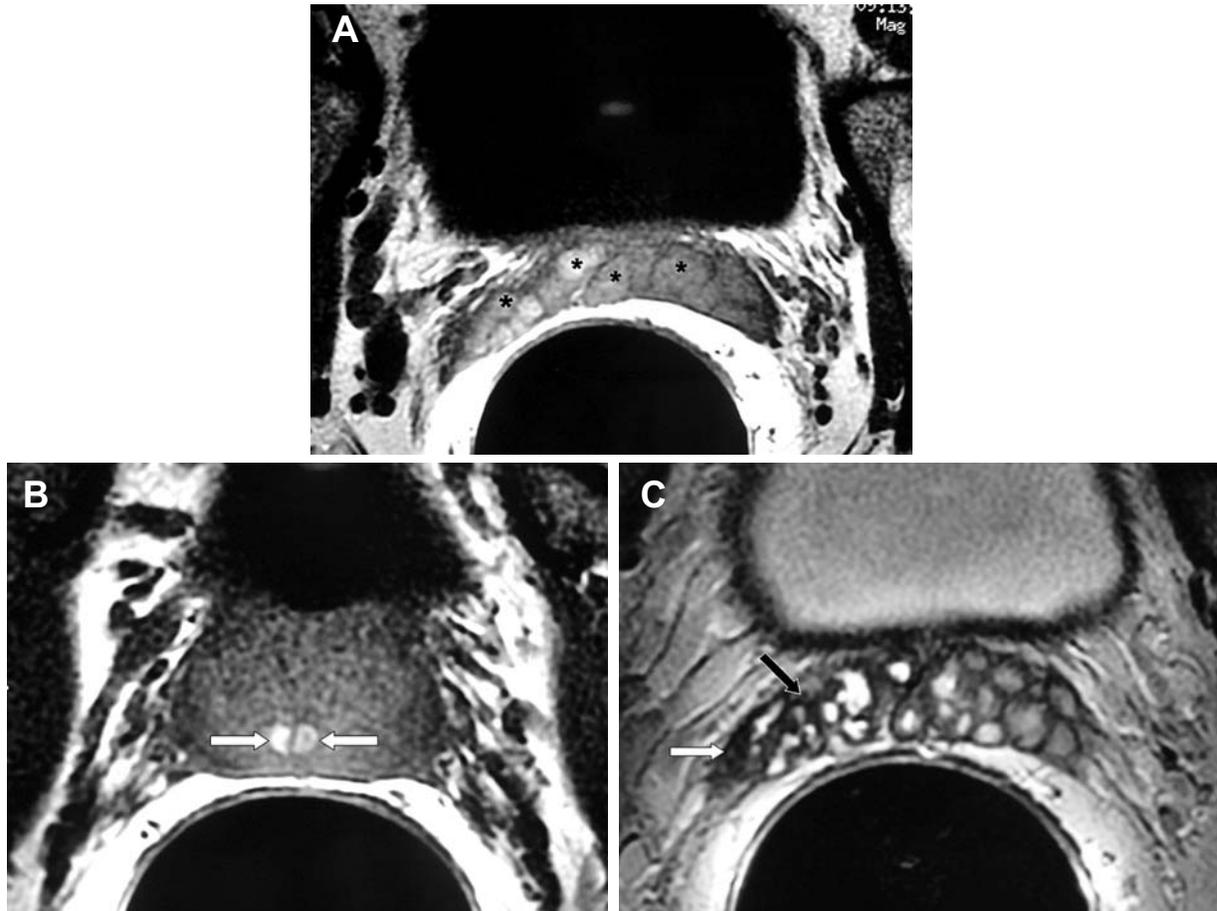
Hemorrhagic chronic seminal vesiculitis. A 62-year-old man, with history of persistent hemospermia and perineal discomfort. A) and B) E-MRI ,axial plane, T1-weighted images. Note high-signal intensity hemorrhage in both seminal vesicles (asterisk) and in both ejaculatory ducts (white arrows). C) and D) E-MRI, axial plane, T2-weighted images ,showing imaging features consistent with chronic seminal vesiculitis: diffuse thickening of the of the seminal vesicles with low T2-weighted signal intensity (dark arrow) and loss of convolutions(white arrow).These abnormalities are more evident in the right seminal vesicle which appeared contracted in comparison with the left seminal vesicle.
